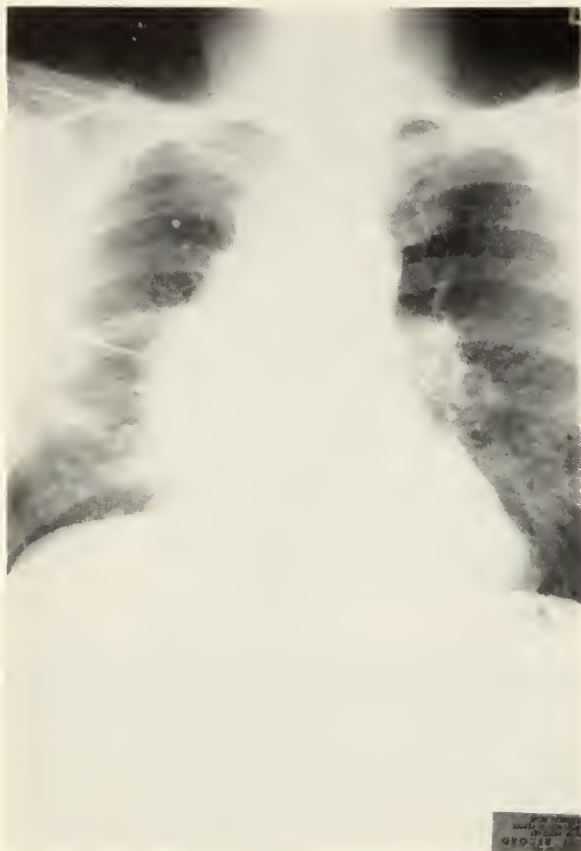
Chest x-ray on initial admission showing a large mediastinal mass, found to be unresectable malignant thymoma (Case I).
